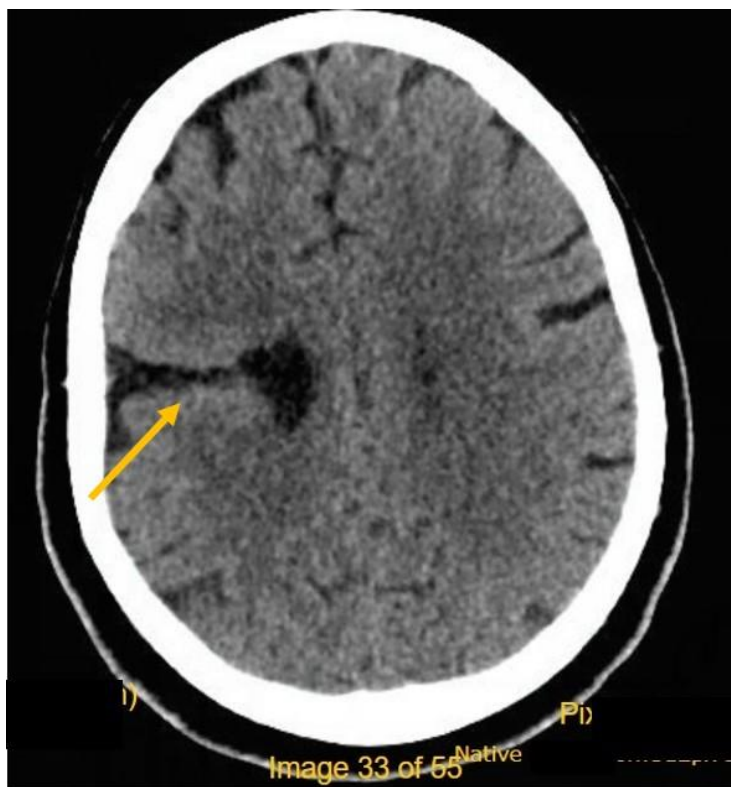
Axial cranial computed tomography scan showing a cleft filled with cerebrospinal fluid in the right cerebral hemisphere, consistent with open-lip schizencephaly.
